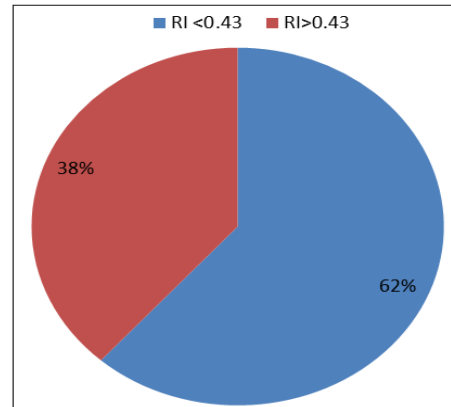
Significant Doppler findings in malignant lesion
